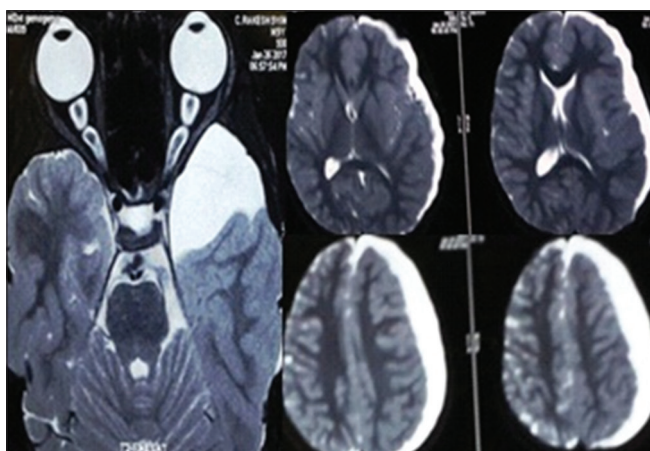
Magnetic resonance imaging brain T2 W image showing subdural hyperintensity in the left frontotemporal region and left middle cranial fossa suggestive of arachnoid cyst with subdural hygroma and mass effect
